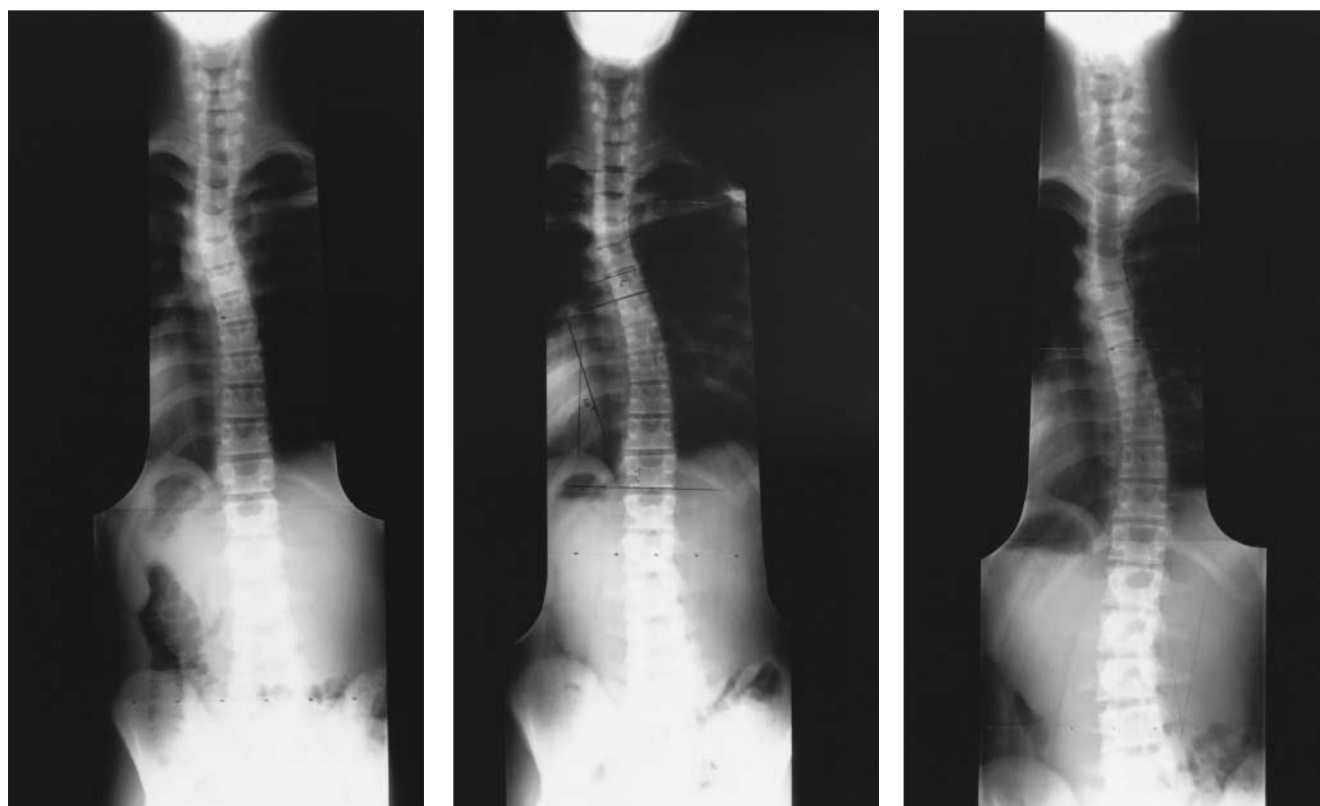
Case 3. The radiograph of this child's spine at the age of 14 years 9 months demonstrates an upper thoracic curve, convex left, measuring 27° (left). At 15 years of age the child has a double curve, with an upper thoracic curve, convex left, measuring 22° and lower thoracic curve, convex right, measuring 20° (centre). At 17 years, 5 months, there is a triple curve, with an upper thoracic curve, convex left, of 24°, a middle thoracic curve, convex right, of 22° and a lumbar curve, convex left, of 18° (right).
